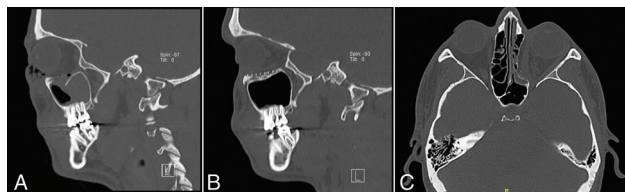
(A) Initial sagittal computed tomography (CT) showing isolated left orbital floor fracture with fluid in maxillary sinus. (B) Subsequent sagittal CT scan demonstrating the left orbital floor reconstruction with titanium-reinforced porous polyethylene implant after secondary trauma. (C) Axial CT demonstrating left medial orbital wall blowout fracture after secondary trauma.
